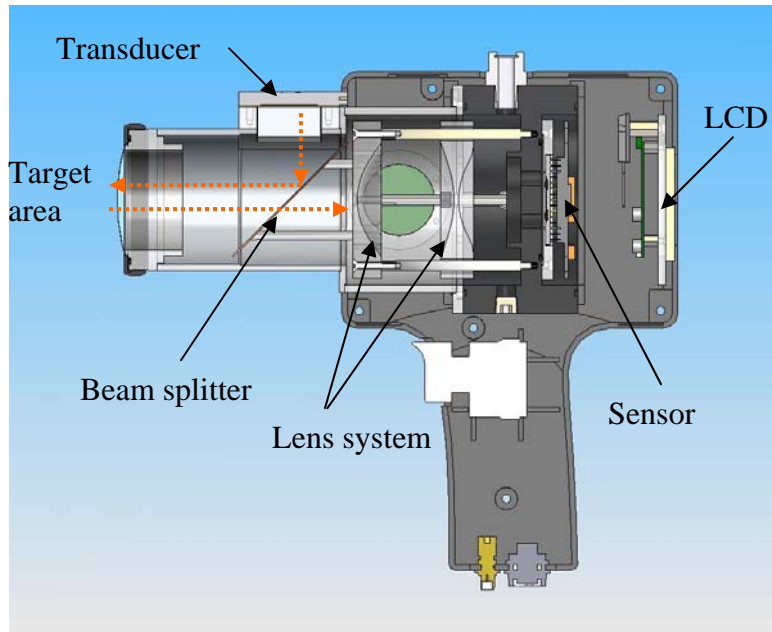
A blueprint of the handheld C-scan reflection ultrasound device.
